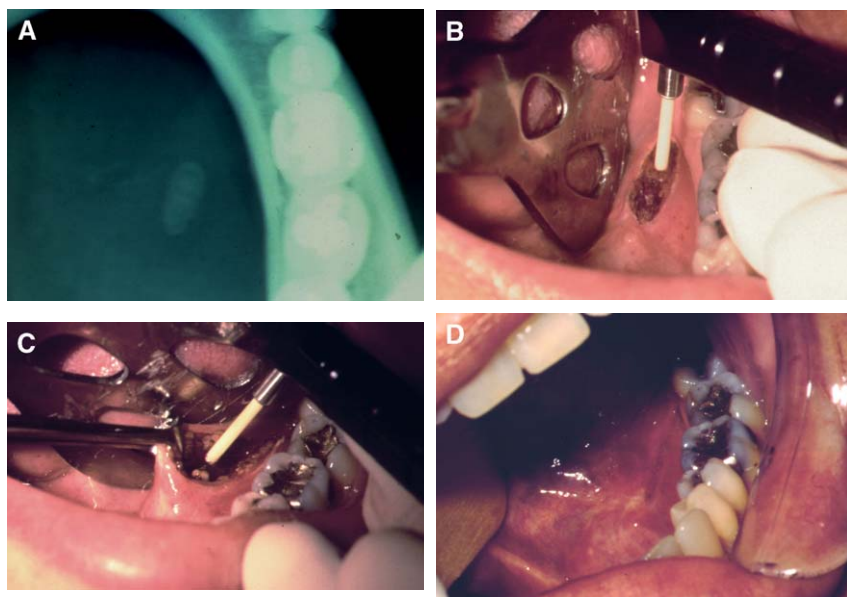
Salivary calculi removal. (A) Occlusal radiograph showing radiopaque mass consistent with a sialolith. (B) Excision of floor-of-mouth mucosa for exposure of sialolith. (C) Calculi visualized (confirmed by production of spark). (D) Resultant tissue defect left unsutured.
